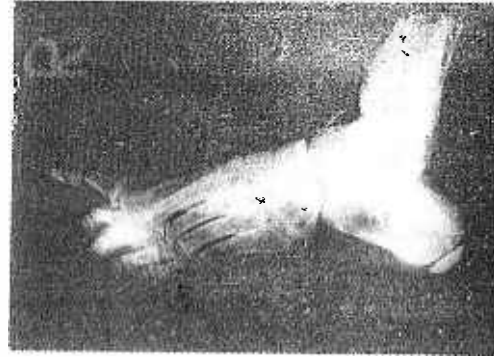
X-ray of a paralytic valgus foot to show incorporation of the graft five years after Grice's operation.
